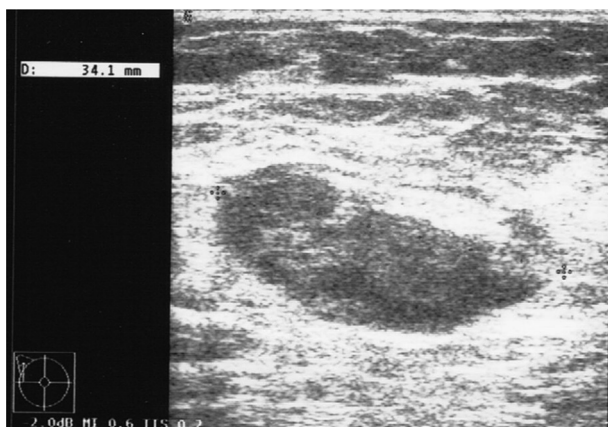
Ultrasonography showing an enlarged (34.1 mm) hypoechoic mass with well-circumscribed margins and fatty echogenic hilum at the level of the right axilla.
